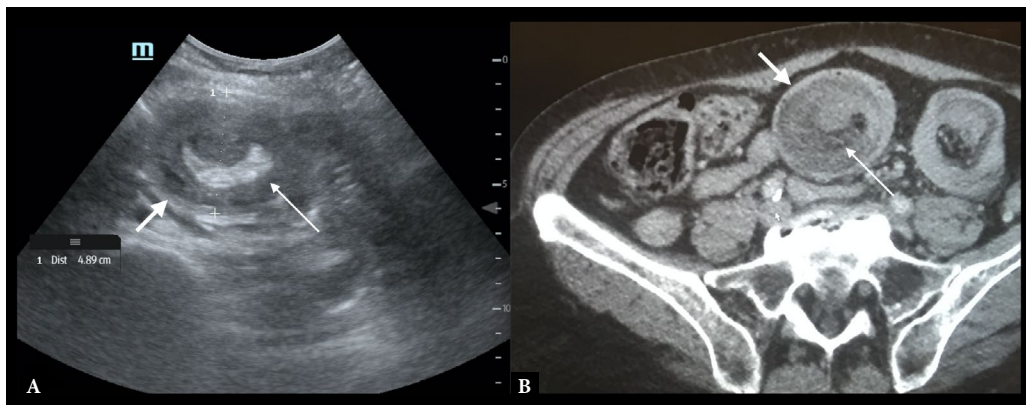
A. Sonographic image and corresponding CT image B. with jejunal intussusception in transverse view showing outer intussusciens (thick arrow) and central intussusceptum (thin arrow)
